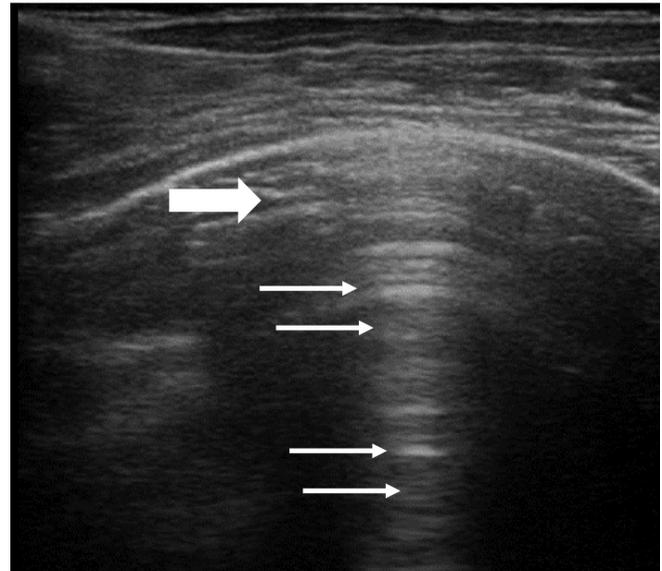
Lung ultrasound findings in a normally aerated lung. It is possible to see the pleural line (white thick arrow) and A-lines (white thin lines)
